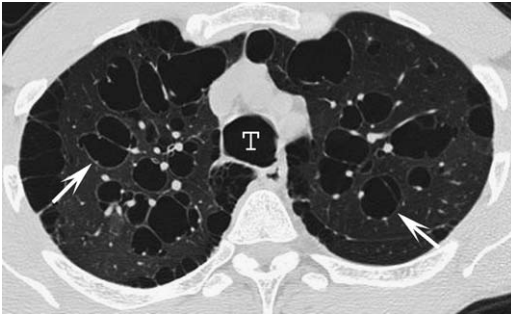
HRCT assessment of bronchiectasis: cystic bronchiectasis. Axial HRCT imaging shows extensive bilateral cystic bronchiectasis (arrows), consistent with the diagnosis of tracheobronchomegaly. Note dilated trachea (T).
